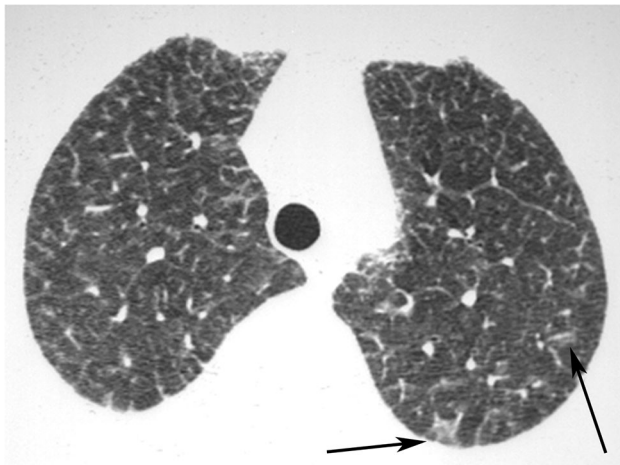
Axial CT image with lung window settings of the upper lung zones shows smooth thickening of the interlobular septa, associated with focal areas of ground-glass opacity (arrows)
